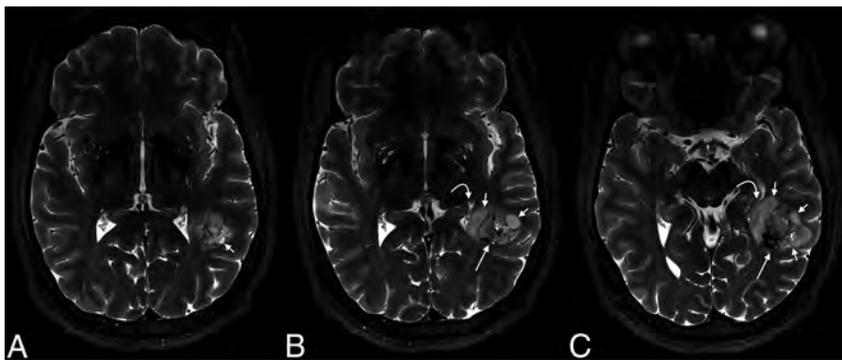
7T MR imaging demonstrates internal characteristics of the mass on T2WI. From left to right (A–C), heterogeneous solid material is seen centrally (*long straight arrows*), while cystic components are located peripherally (*short straight arrows*). Fluid within the cysts is heterogeneous, but typically hypointense to CSF. A mild associated mass effect is seen, including partial effacement of the left lateral ventricle (*curved arrows*).
